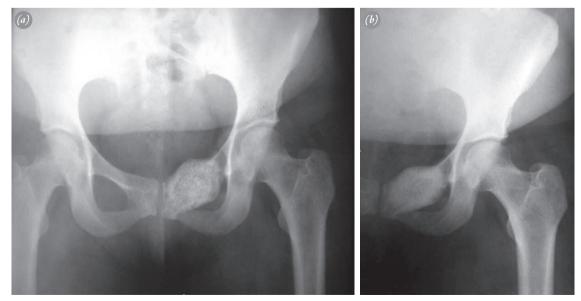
(a) Anteroposterior radiograph of the pelvis at 2-year follow-up, with no recurrence. (b) Anteroposterior radiograph of the pelvis at 6-year follow-up with, no recurrence.
